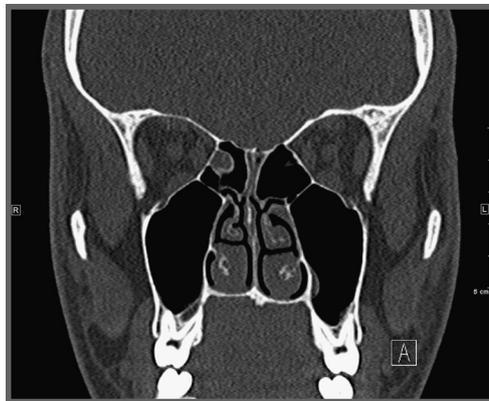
High-resolution sinus CT reveals a small air bubble along the posterior left margin of the crista galli with poor ossification of the cribriform plate on the left side.
